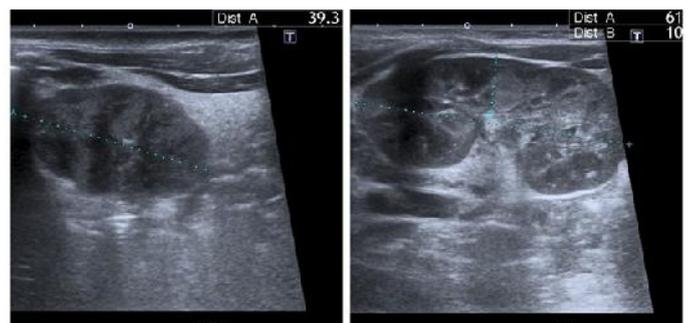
Abdominal ultrasound. Right renal atrophy with increased left longitudinal diameter in relation to compensatory hypertrophy
